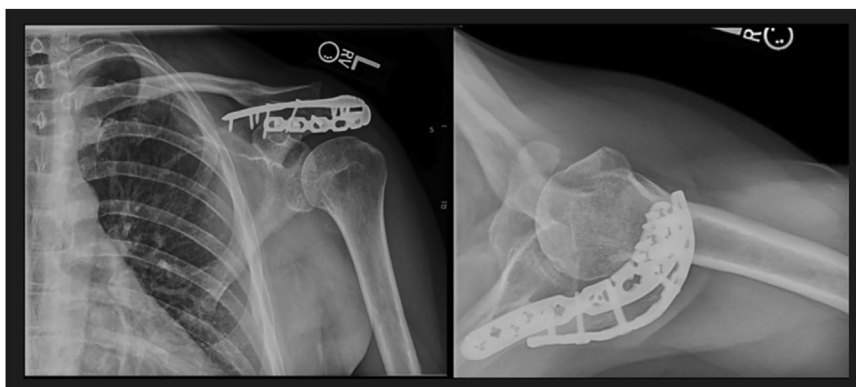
One-year postoperative left shoulder radiographs with anteroposterior and axillary views demonstrating healed acromial fracture, intact hardware, and normal glenohumeral alignment.
